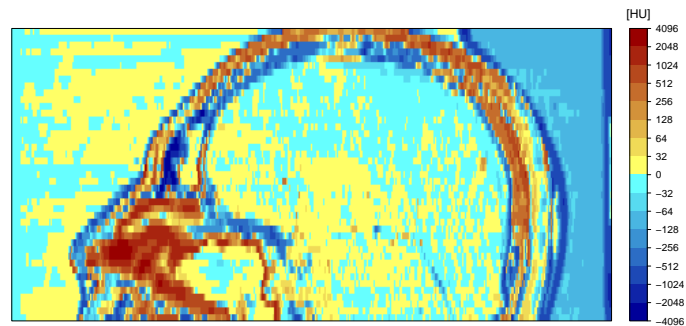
Examples of transversal slices of the head region of patient 2: (a, b) p CT using the best combination of contrasts and additional features; (c, d) r CT; (e, f) difference map from data of (a, c) or (b, d). In the logarithmic color scale, red pixels represent an overestimation and blue pixels an underestimation of the r CT number.
